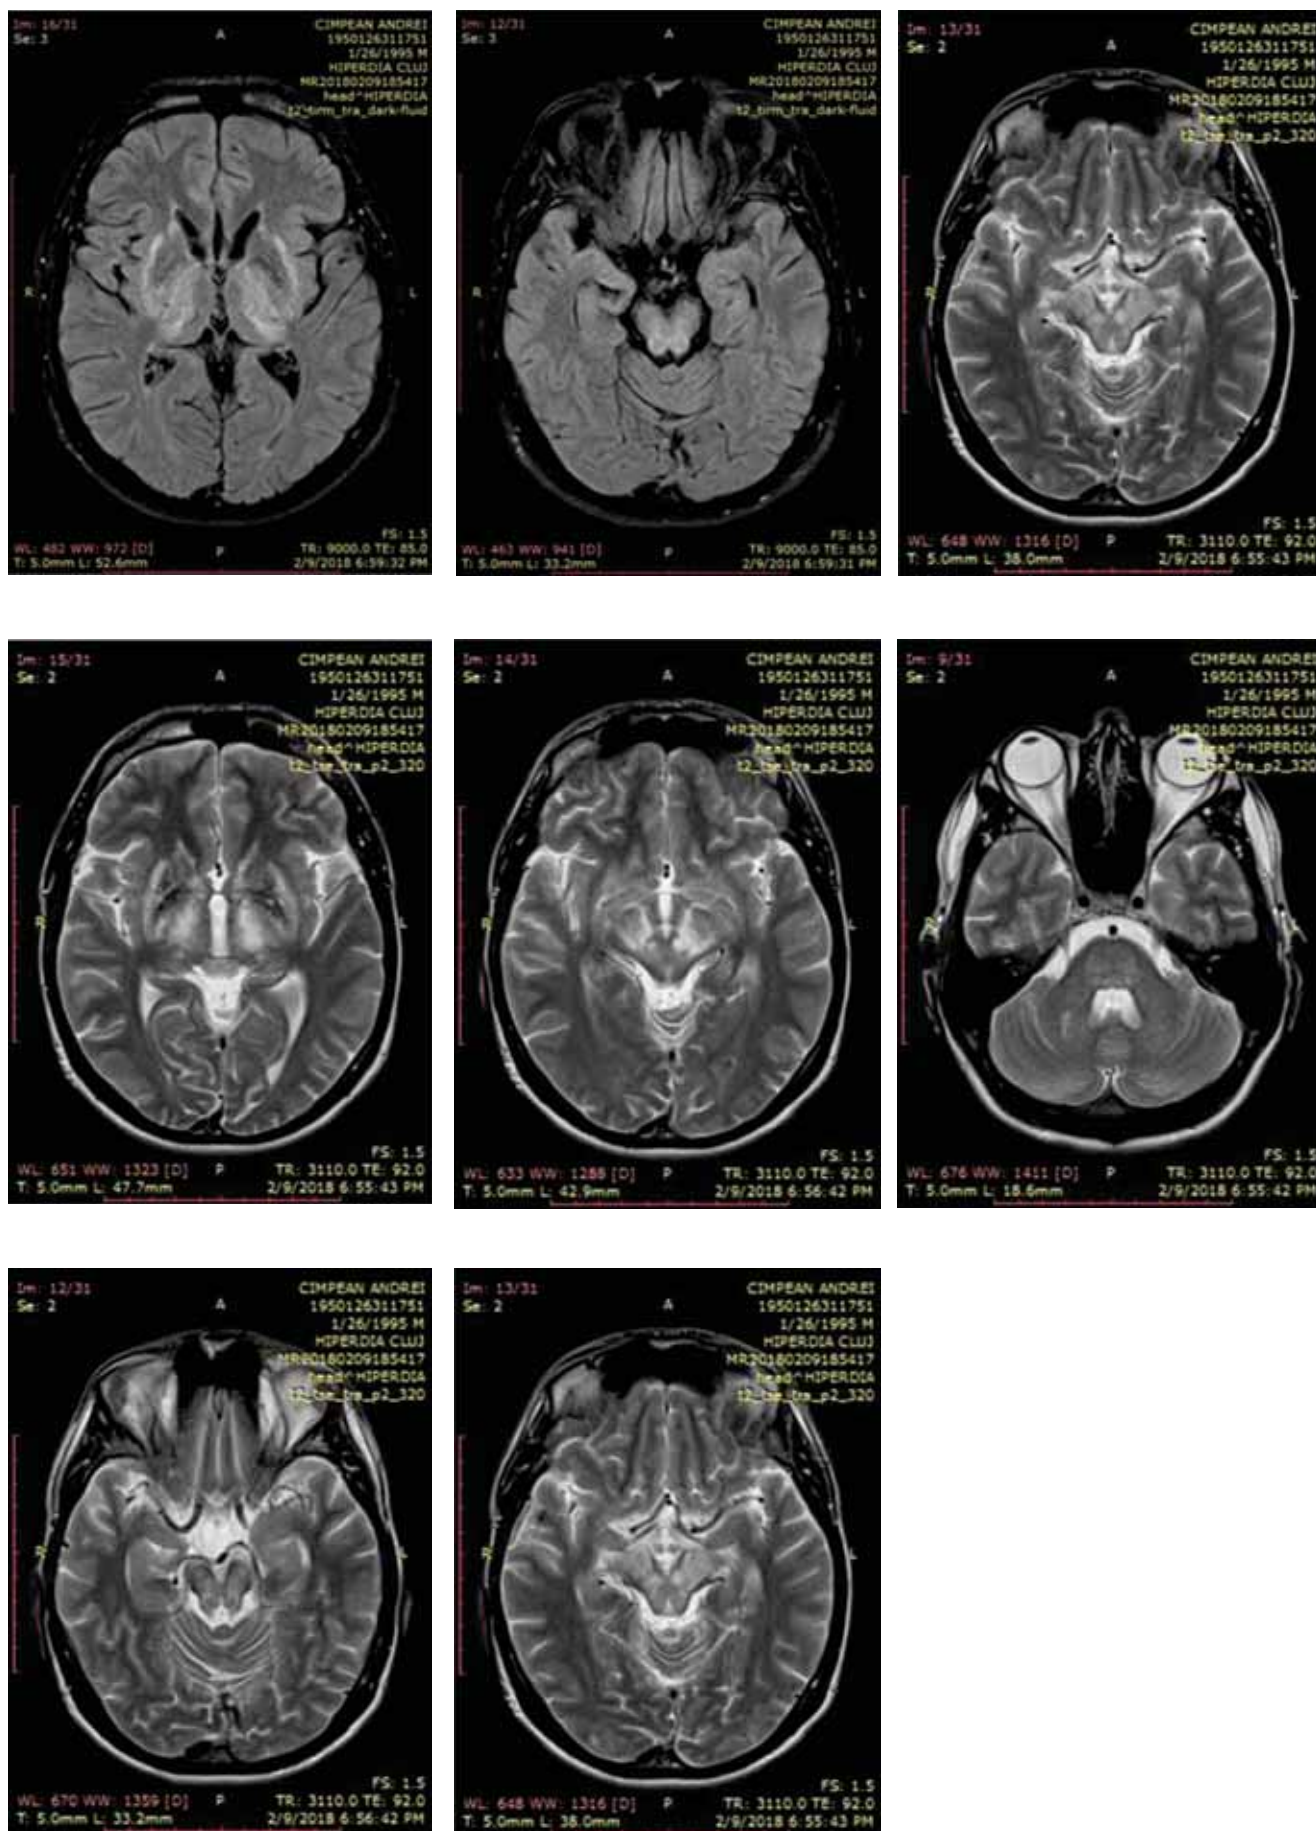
Brain MRI showing hyperintense T2 lesions in the basal ganglia, thalamus and brain stem
